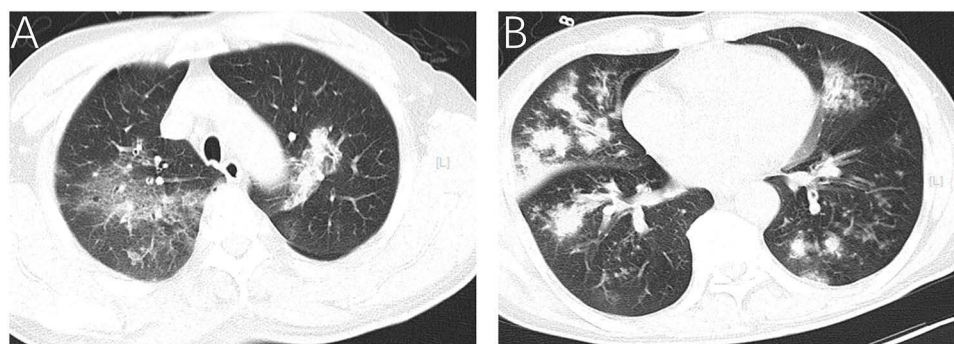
CT Multiple patchy consolidations with ground-glass opacities are seen in the bilateral upper lobes of the lungs (A). The middle and lower lobes show nodules and patchy increased-density opacities, with ill-defined borders and heterogeneous density. (B). [L] indicates the left side of the lung.
